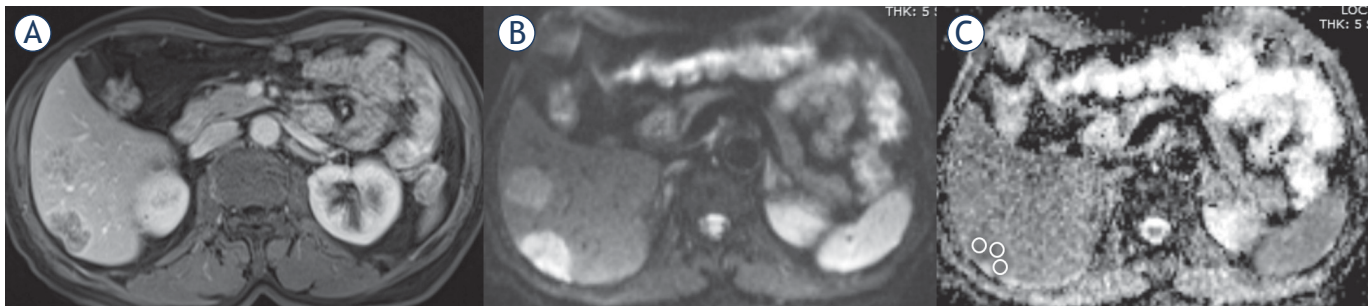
59-year-old male with liver metastases due to colorectal adenocarcinoma. Contrast-enhanced axial T1-weighted (T1W) (A), diffusion weighted image (DWI) obtained at b value of 800 s/mm² (B) and apparent diffusion coefficient (ADC) maps (C) with free hand ROI placement technique.
